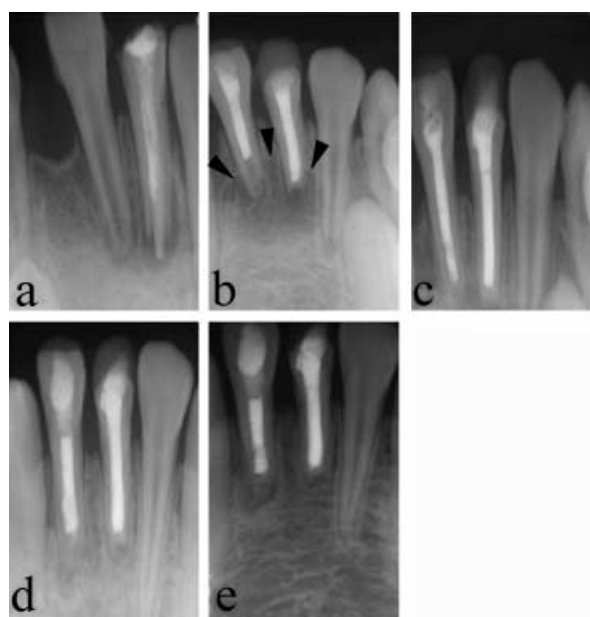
Dental radiographs taken: (a) at the first examination; (b) 5 months after apexification (the arrowhead shows the boundary of the peri-apical lesion near the lower left central incisor); (c) 2 months after intentional replantation; (d) 5 months after intentional replantation; and (e) 5 years after intentional replantation.
